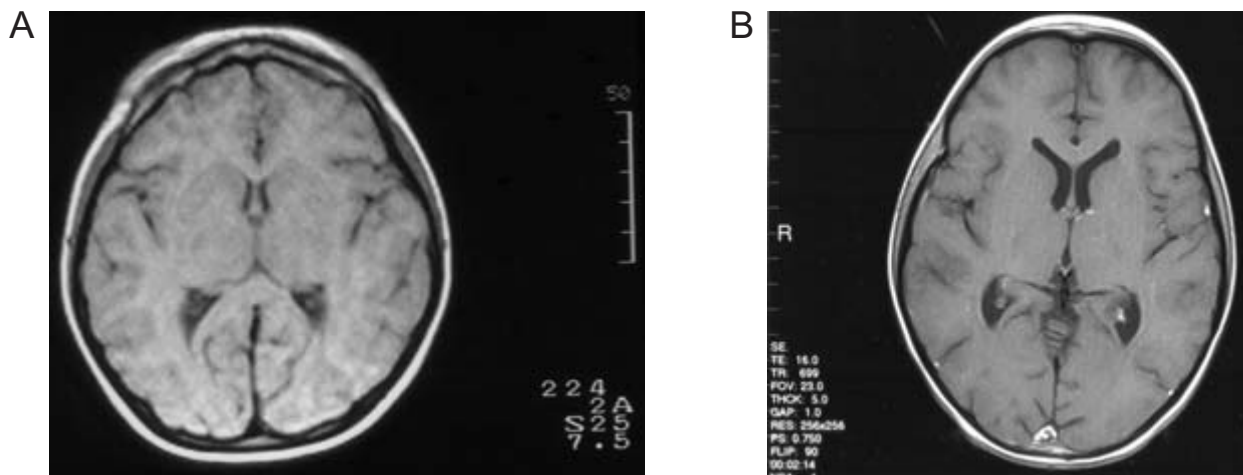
(A) Patient no. 3. Axial T1-weighted image. Decreased size of the frontal lobes and narrow frontal horns of the lateral ventricles. (B) Axial T1-weighted image of an age-matched healthy individual.
